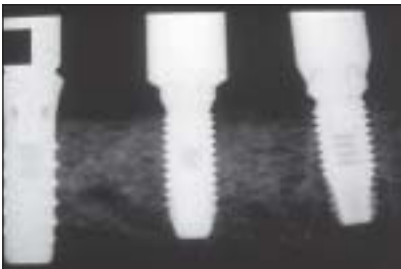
Radiographic view at baseline of (left to right) a TPS implant, an HA-coated implant, and an acid-etched implant. Note the absence of radiolucency around all 3 experimental implants.
